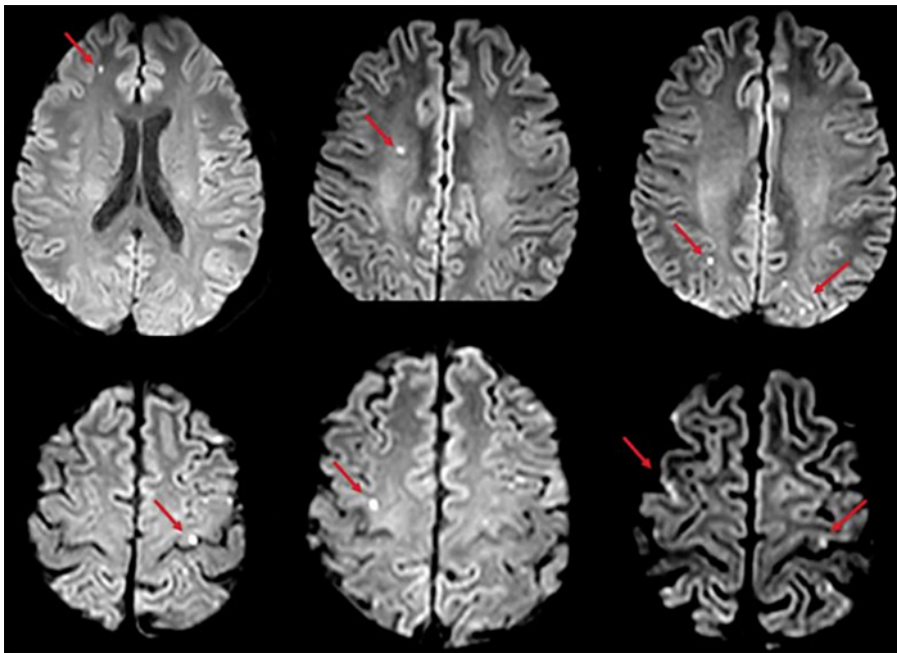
MRI of the brain exhibiting multiple foci with hypersignal and diffusion restriction, suggestive of acute/subacute ischemia (red arrows).
